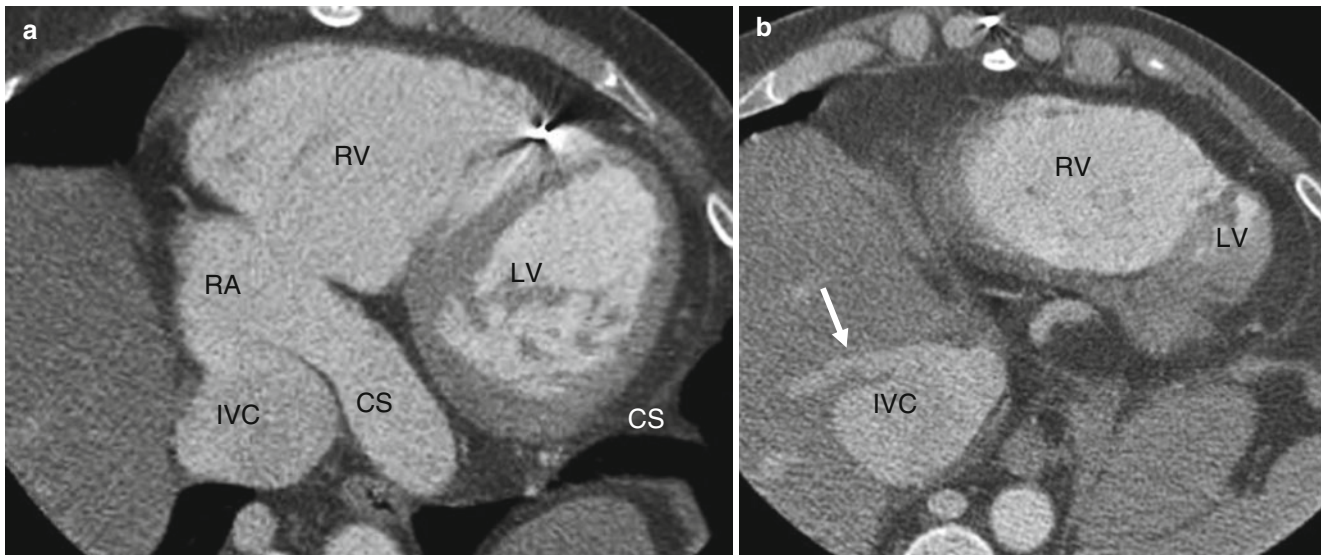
Panels (a) and (b) are CTA images in a patient with tricuspid atresia associated with severe right ventricle dysfunction and enlargement and tricuspid regurgitation. Note the markedly dilated inferior
